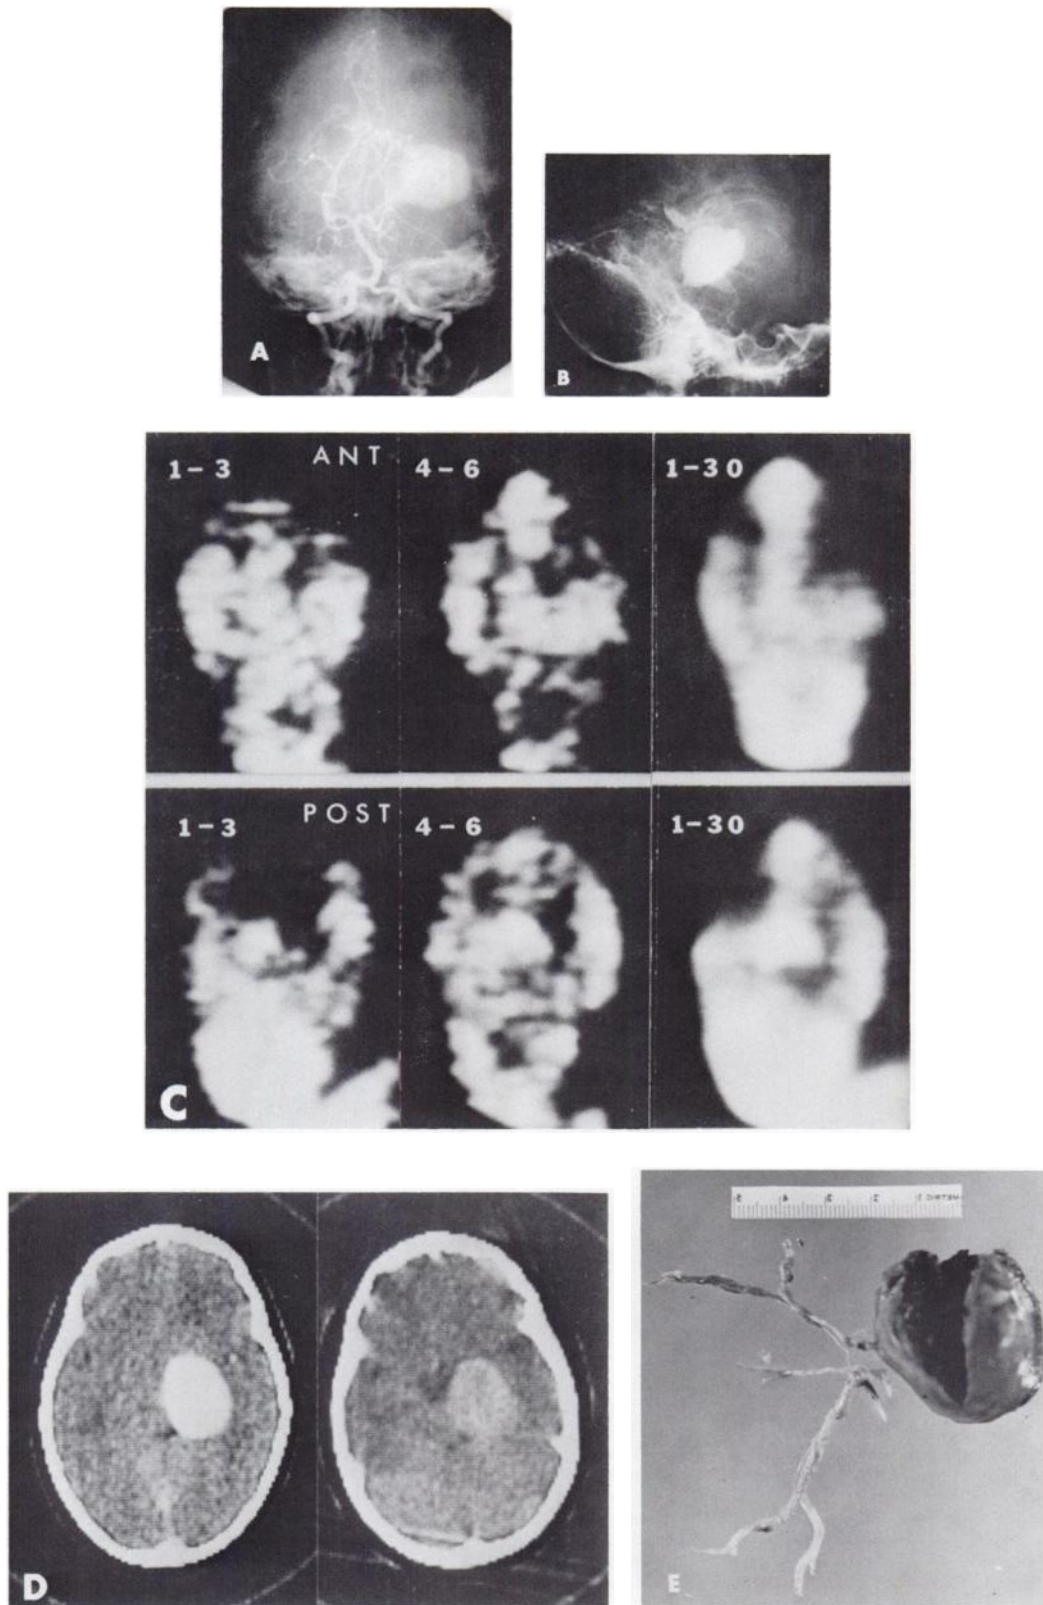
Boy, aged 2½ yr. (Patient 9) with aneurysm arising from right posterior cerebral artery (RPCA). AP vertebral angiogram (A), reversed to be similarly oriented to posterior scintigram and CT scan, shows jetting of contrast into aneurysm from RPCA. A late lateral view (B) shows retention of contrast in aneurysm long after surrounding veins had emptied. (C) Anterior and posterior dynamic scintigrams show vascular lesion on right (not to be mistaken for torcular Herophili on posterior study). (D) CT scan immediately following contrast injection, and another 4½ hr later, show aneurysm. (E) Aneurysm ruptured the night before surgery. Its size and location were dramatically demonstrated at autopsy, when the circle of Willis was dissected and removed.
